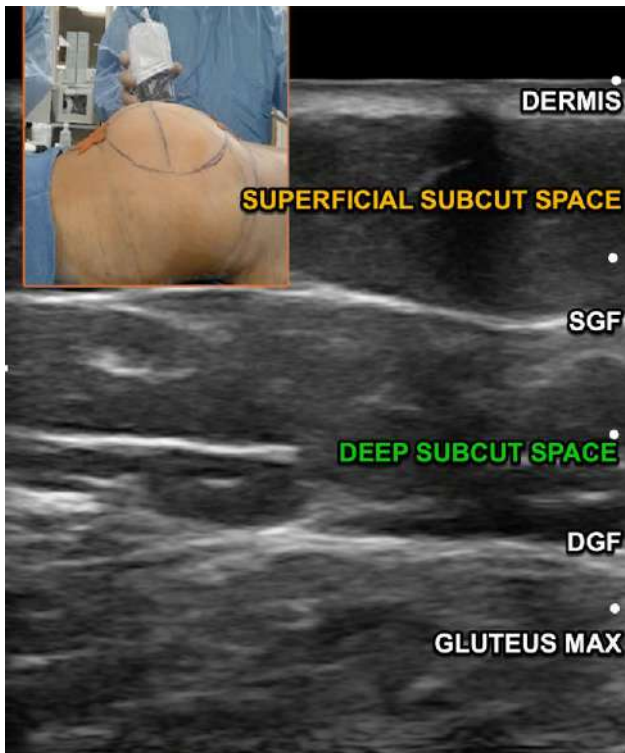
Ultrasound image of key gluteal anatomic landmarks. The dermis is seen at the top of the image abutting the surface of the ultrasound probe. The striated muscle of the gluteus maximus is at the bottom of the image. The DGF (white arrow) is the thick and uniform fascia layer overlying the gluteus maximus muscle. The SGF has the appearance of bubble wrap and is impregnated with fat globules. The SGF divides the subcutaneous zone into the superficial subcutaneous space and the deep subcutaneous space. DGF, deep gluteal fascia; SGF, superficial gluteal fascia.
